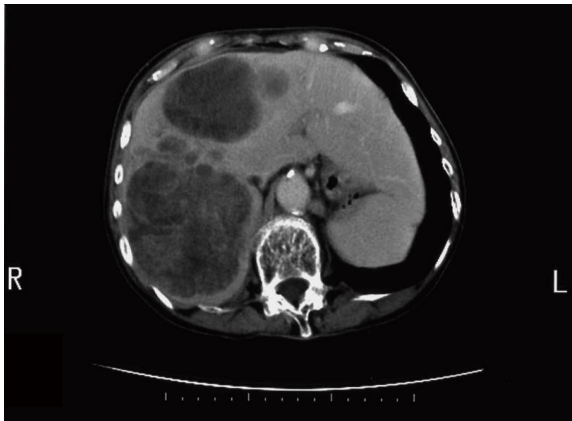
Contrast-enhanced computed tomography image of liver metastasis of protein induced by vitamin K absence or antagonist II -producing gastric cancer. Multiple low density nodules, which are poorly enhanced, are observed in the liver.
